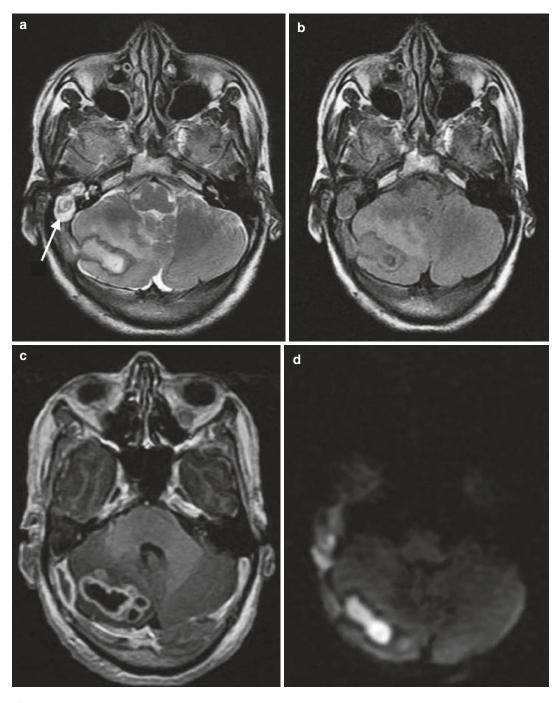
MRI of the brain showing a right cerebellar conglomerate lesion which is hyperintense on T2W (a) and iso- to hypointense on T2-FLAIR (b) with an evidence of parameningeal collection on T1-gadolinium-contrast sequence (c). Restriction on DWI is evident (d).
